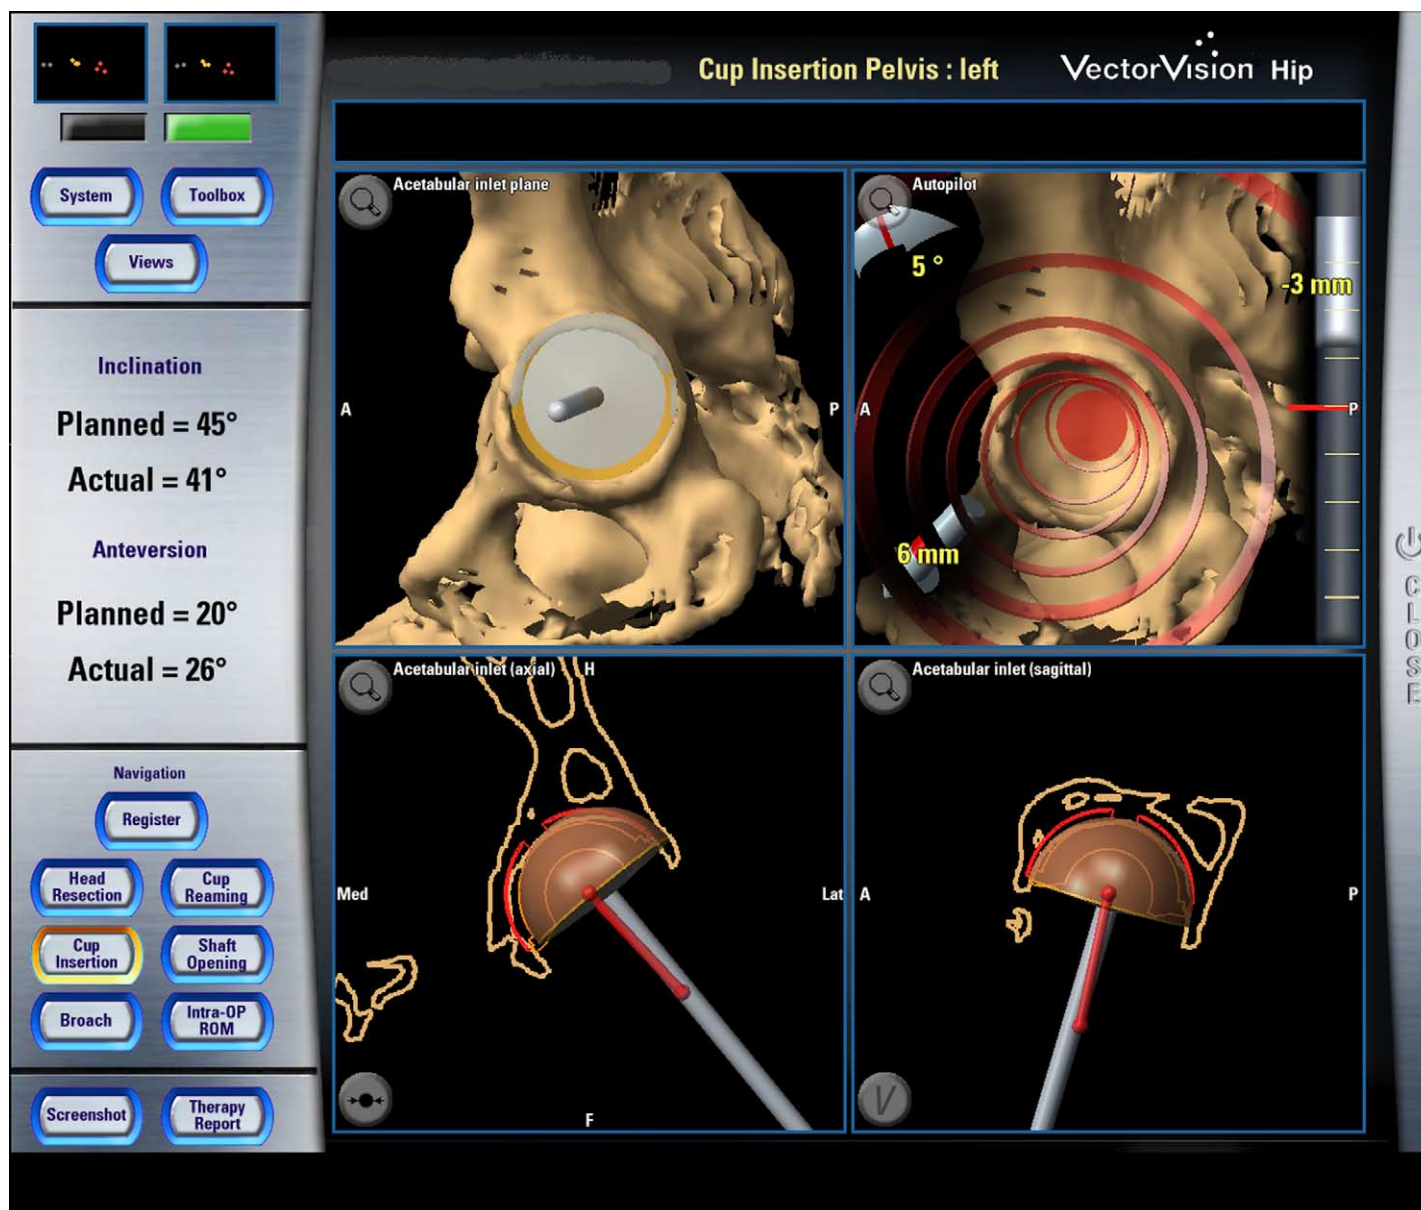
The display of CT-based cup navigation during insertion of the acetabular component. (Color version of figure is available online.)
